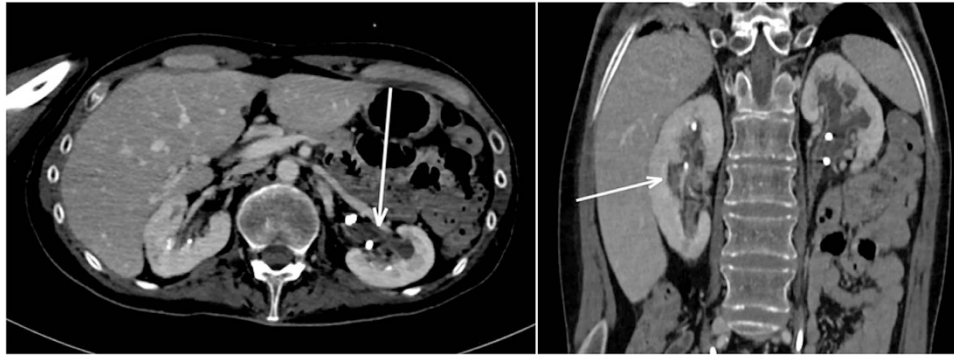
CT scan revealing dilated pyelocaliceal cavities, with infiltrative lesion of the parenchyma (white arrows) compatible with acute pyelonephritis, multiple bilateral nephrolithiasis and double J catheter.
